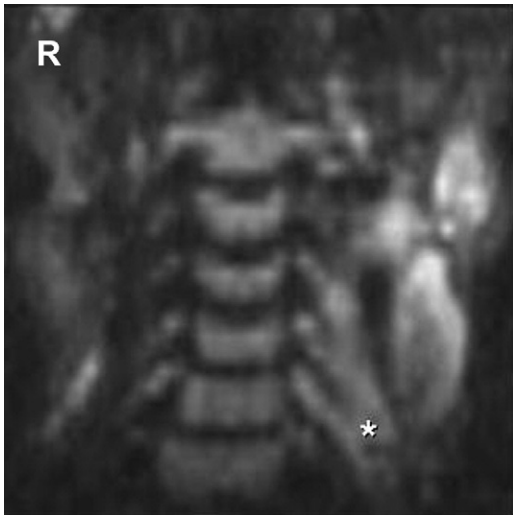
Diffusion-weighted magnetic resonance image, coronal view, obtained 15 days after surgery demonstrates swelling of the brachial plexus on the left (asterisk). There is persistent swelling of the ipsilateral soft tissue.
